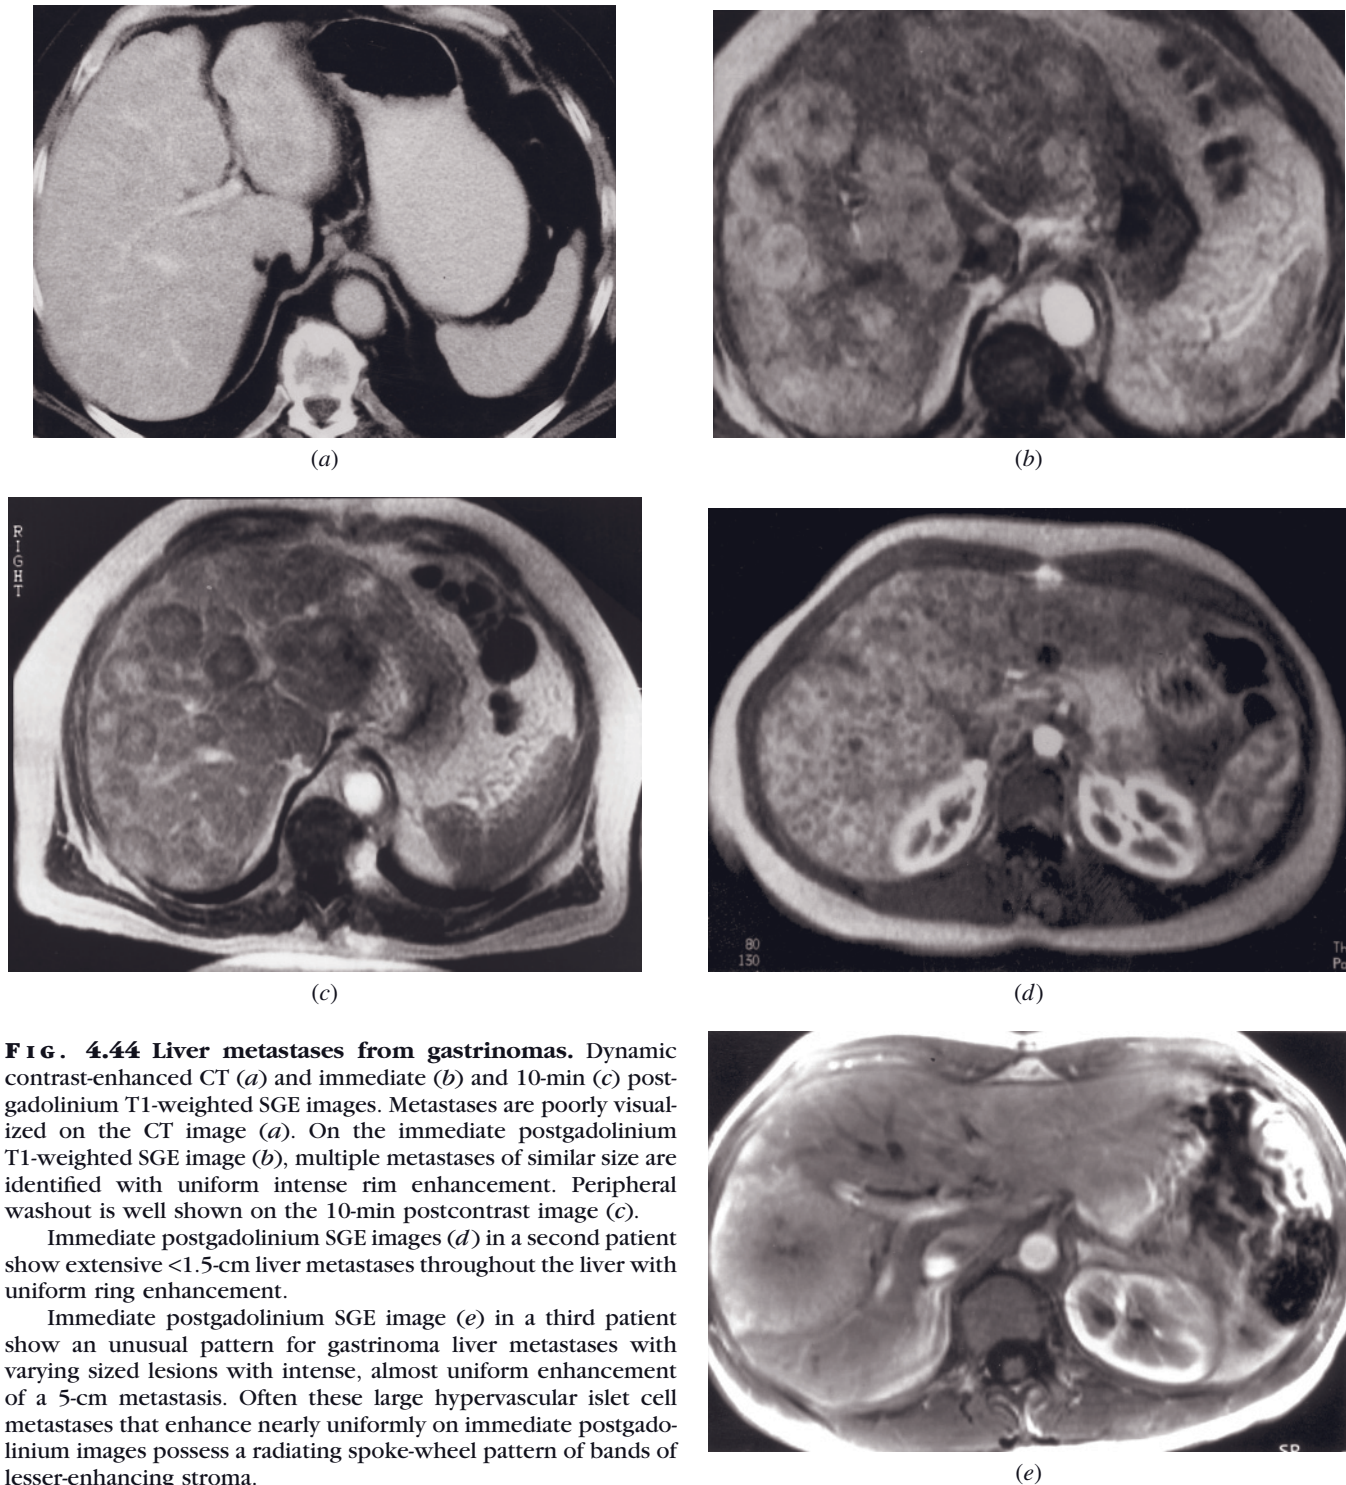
Liver metastases from gastrinomas. Dynamic contrast-enhanced CT (*a*) and immediate (*b*) and 10-min (*c*) postgadolinium T1-weighted SGE images. Metastases are poorly visualized on the CT image (*a*). On the immediate postgadolinium T1-weighted SGE image (*b*), multiple metastases of similar size are identified with uniform intense rim enhancement. Peripheral washout is well shown on the 10-min postcontrast image (*c*).
